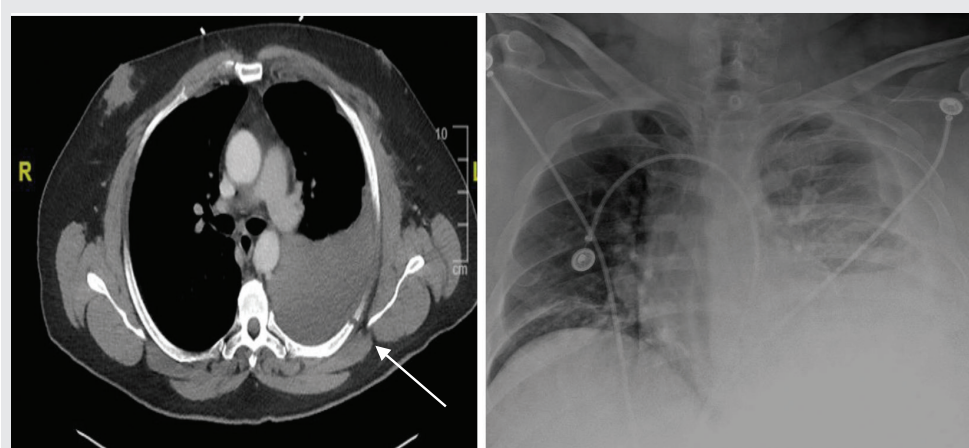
Chest x-ray and CT scan of the patient showing a left-sided rib fracture (arrow) and large left-sided pleural effusion.
